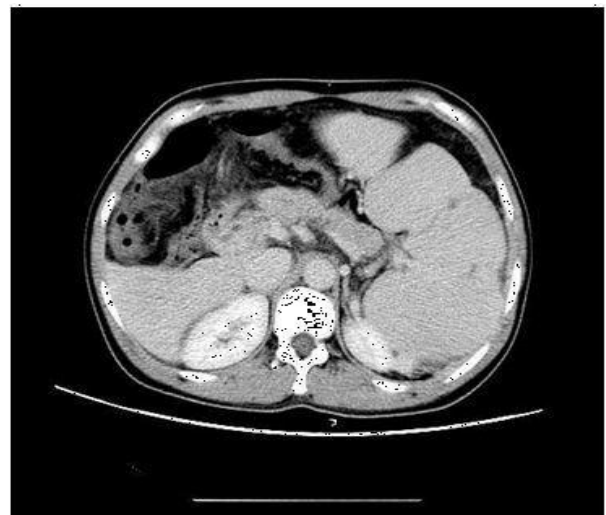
CT found the stenosis spleen vein and major portal vein thrombosis.
